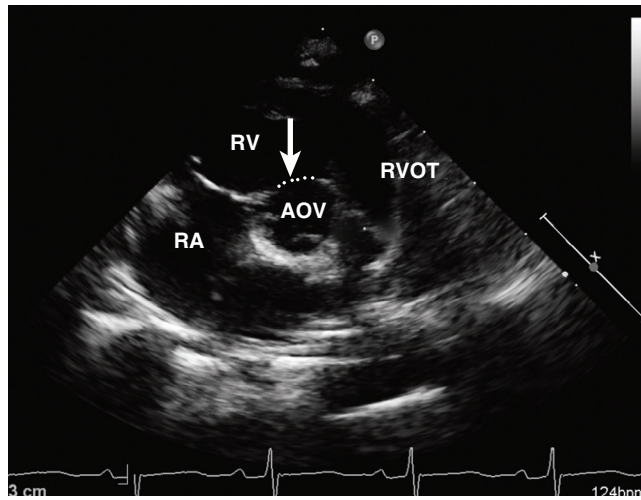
■ Preoperative two-dimensional echocardiographic image, short-axis view, showing the deviation of the infundibular septum creating the interventricular communication (white dots) and the obstruction at the right ventricular outflow tract (RVOT). AOV, Aortic valve; RA, right atrium; RV, right ventricle. (Courtesy Professor Ornella Milanese.)
